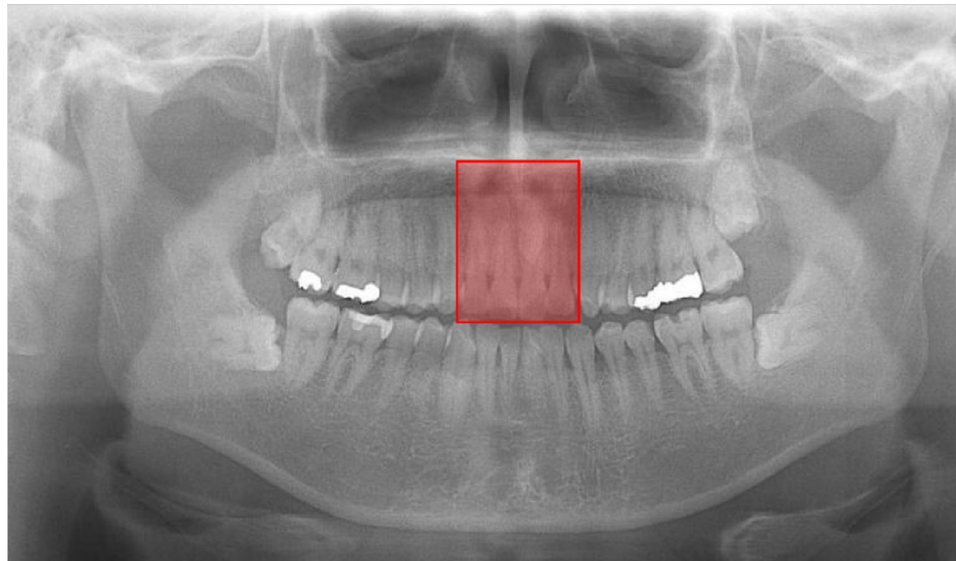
An example of a successfully detected and classified panoramic radiograph. The maxillary incisor region is correctly detected. The detected region is shown as a red rectangle, indicating that the model correctly assigns it as class 0 with an impacted supernumerary tooth.
